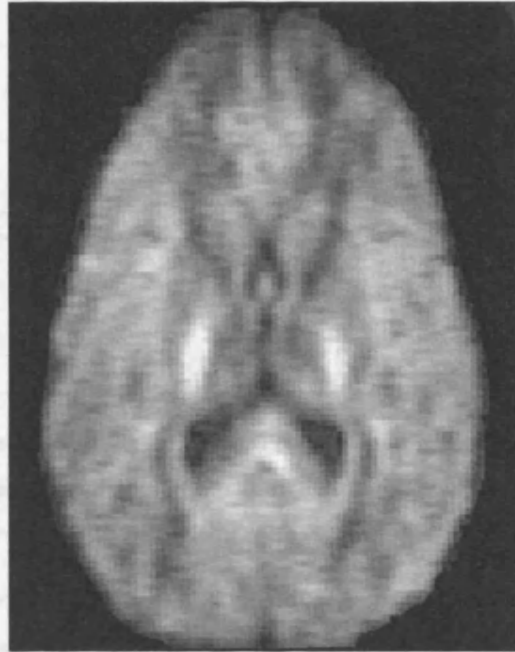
DWI shows areas of unrestricted diffusion, such as CSF filled ventricles, as dark.
